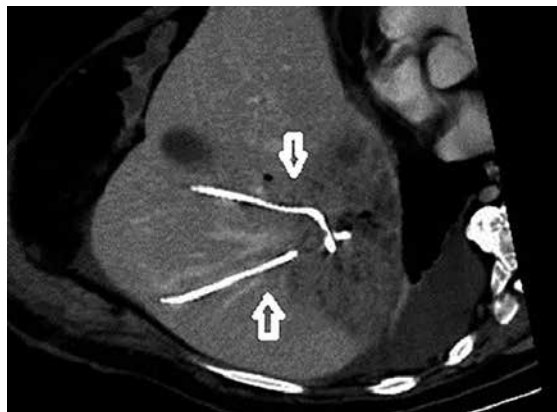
Insertion of pigtail stents into the hepatic abscess. CT of the abdomen showing two pigtail stents inserted into the hepatic abscess. The arrows are demonstrating the pigtail stents.
